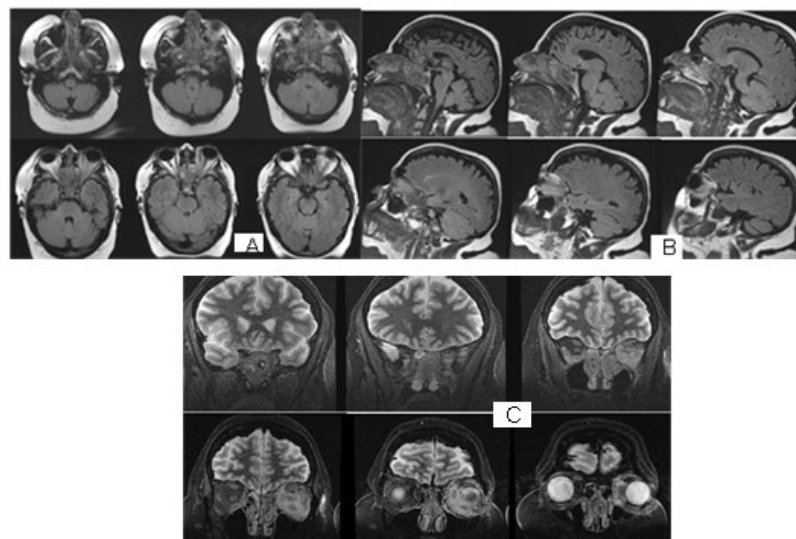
A/B) Axial and sagittal MRI/March 2021-The brain substance of T2-FLAIR and other sequences are with isointense signal without changes in the brain ventricles. Rightly, a 14 mm/6 mm soft-tissue formation is visualized, destroying adjacent bones, engaging the sphenoid sinus and ethmoid sinuses bilateral, entering the two nasal passages, more in the right, and infiltrating the left retrobulbar space;C) Coronal MRI.
